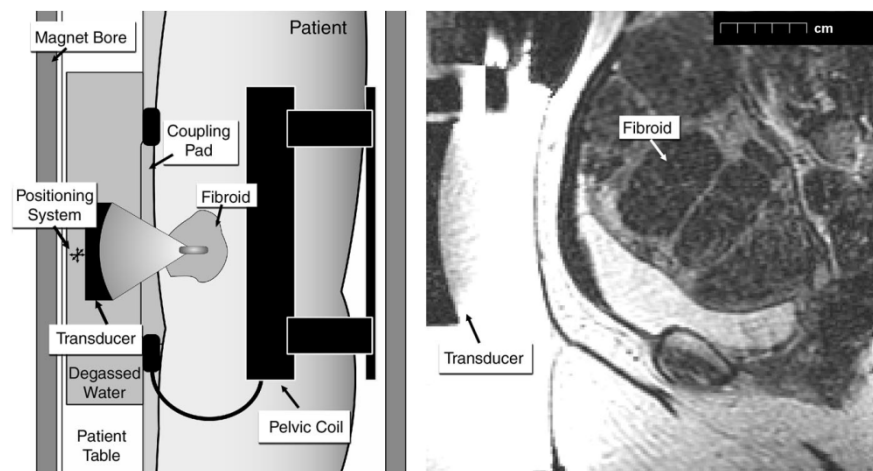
High Intensity Focused Ultrasound [18]
